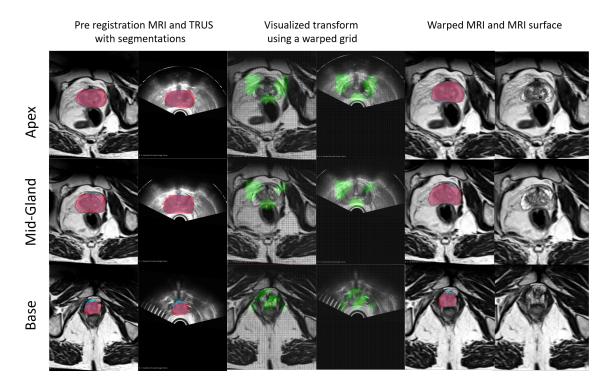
Sample MRI-TRUS registration results for a second patient using 3D segmented surfaces as landmark and B-spline grid to warp the MRI on the targeted TRUS. The blue segmented area represents the prostate surface on TRUS image and the red area annotates the prostate gland on MRI.
